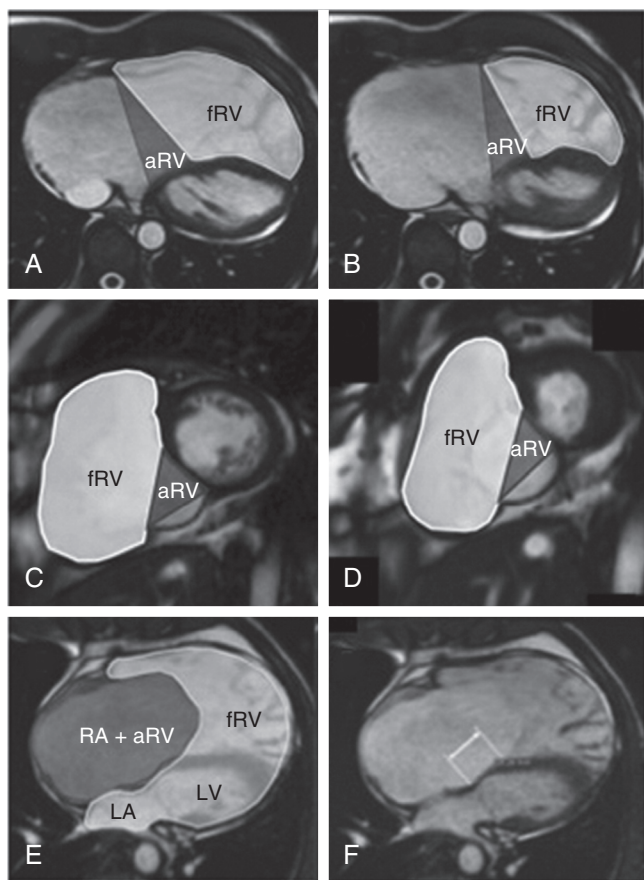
■ Cardiac magnetic resonance imaging showing systolic and diastolic contours of functional right ventricle and atrialized portion of the right ventricle in (A and B) axial and (C and D) short-axis views. E, Severity index representing the ratio of areas of the right atrium and atrialized right ventricle in numerator and summation of functional right ventricle and left atrium and left ventricular areas in denominator (i.e., Severity index = [Right atrial area + Atrialized right ventricular area] / [Functional right ventricular area + Left atrial area + Left ventricular area]). F, Degree of apical displacement of septal leaflet of tricuspid valve (in millimeters) measured in ventricular diastole. aRV, Atrialized right ventricle; fRV, functional right ventricle; LA, left atrium; LV, left ventricle; RA, right atrium. (A-D from Yalonetsky S, Tobler D, Greutmann M, et al: Cardiac magnetic resonance imaging and the assessment of Ebstein anomaly in adults. *Am J Cardiol* 107:767-773, 2011, Figure 2.)
